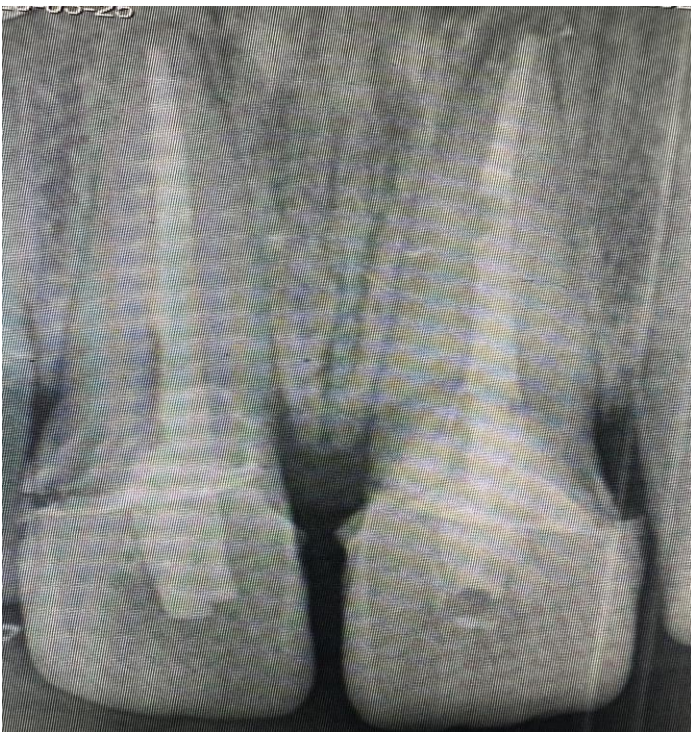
Post operative IOPA radiograph
